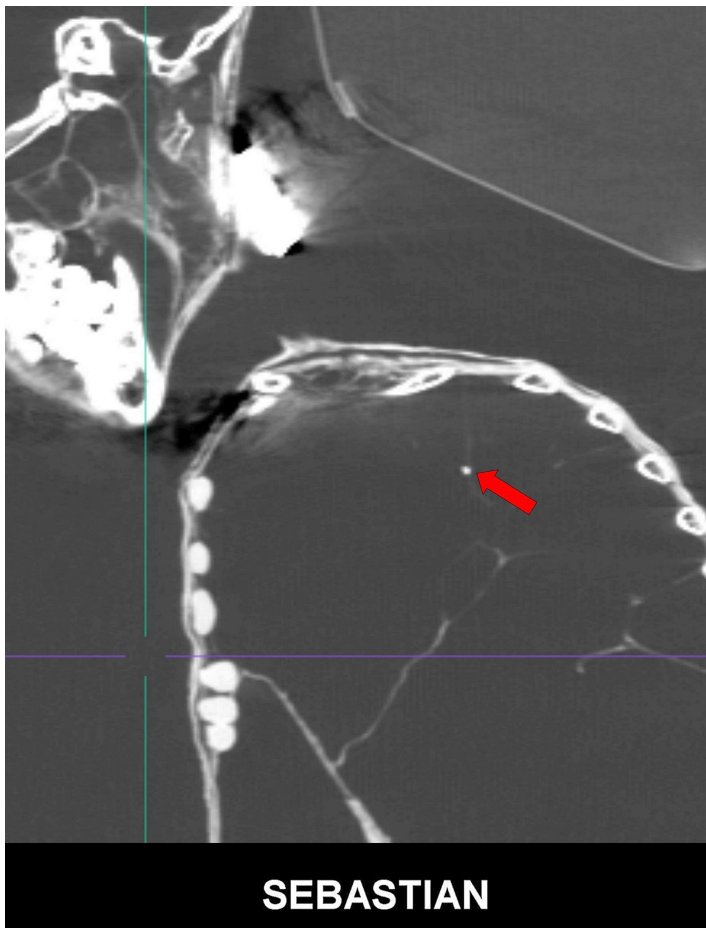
2D sagittal CT scan showing calcified focus (*red arrow*) in upper lobe of left lung. Possibility of inactive pulmonary tuberculosis cannot be ruled out.
